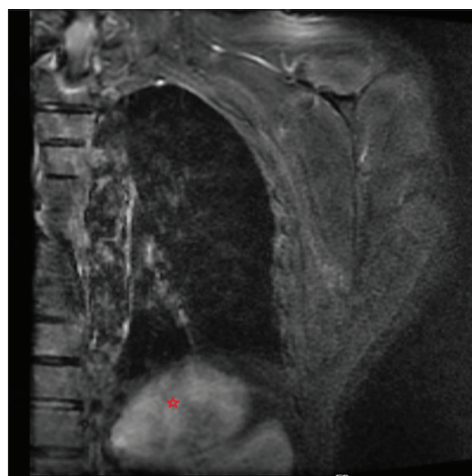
Magnetic resonance imaging thorax showing well-defined lesion in the subscapular region (red star)
